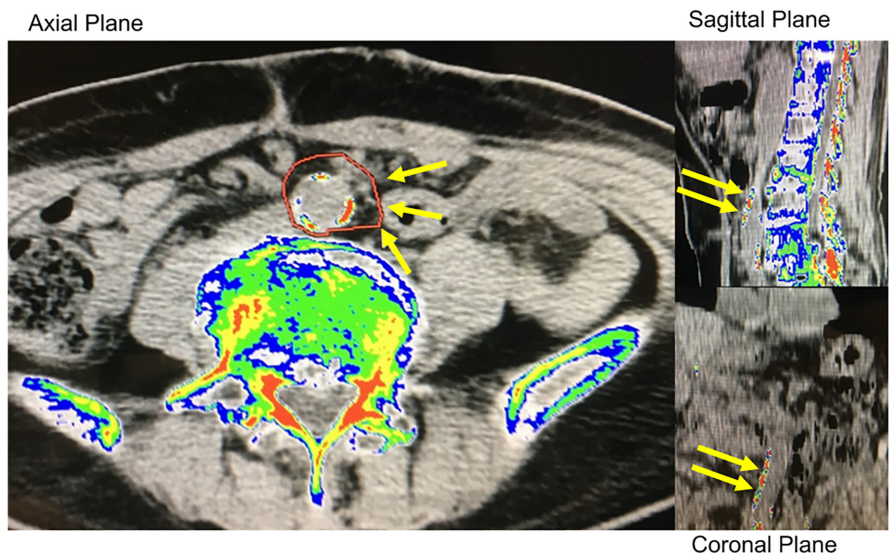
Abdominal aortic calcification evaluation using computed tomography scans.
